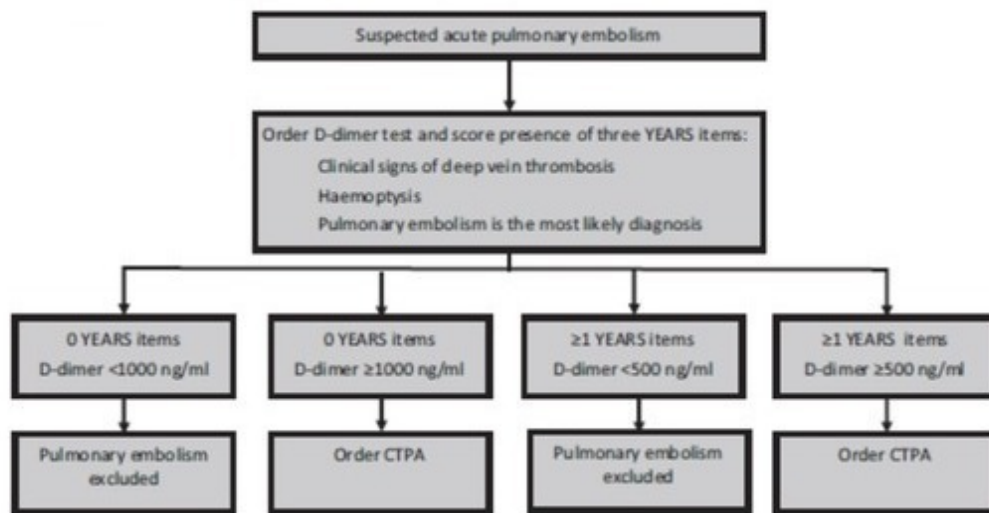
YEARS algorithm. CTPA, computed tomography pulmonary angiography.
